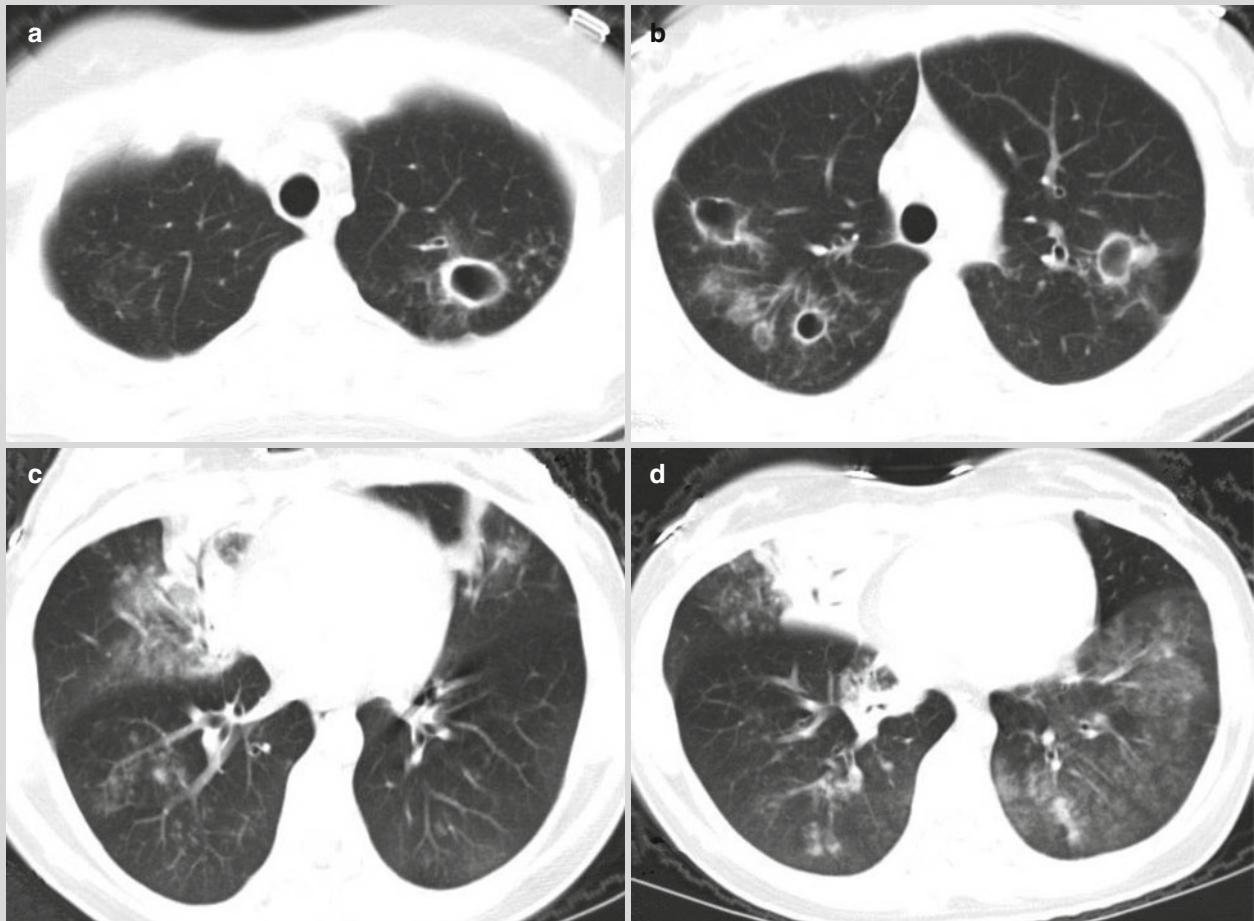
CT scan showed multiple irregular thin-wall cavities in the bilateral upper lung lobes, which was surrounded by sporadic patches of opacity; bronchial wall thickening in the left upper lung lobe, with widened bronchial lumen (a, b). CT scan showed multiple
